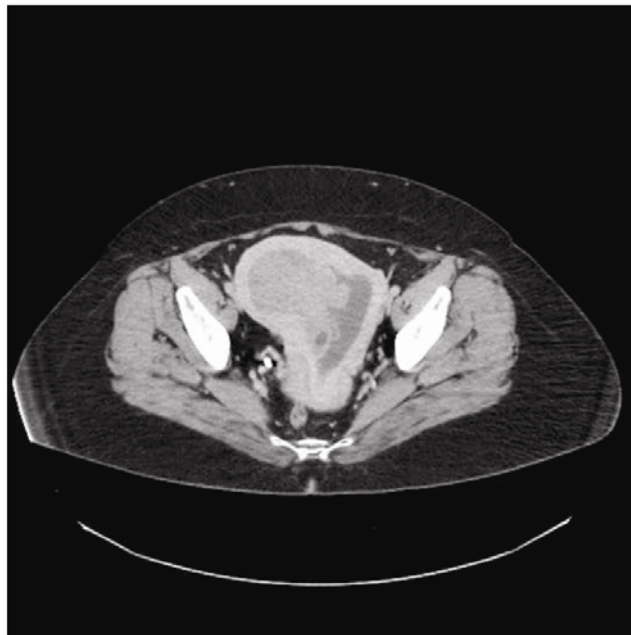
CT Abdomen/Pelvis with IV and Oral Contrast. Uterine mass measuring 8.3 cm × 6.9 cm × 5.6 cm consistent with endometrial neoplasm.
